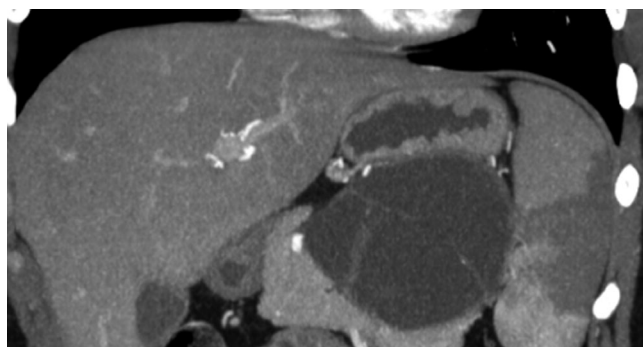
Reformatted CT demonstrating a mucinous cystic neoplasm indenting the stomach. Note the presence of septations.
